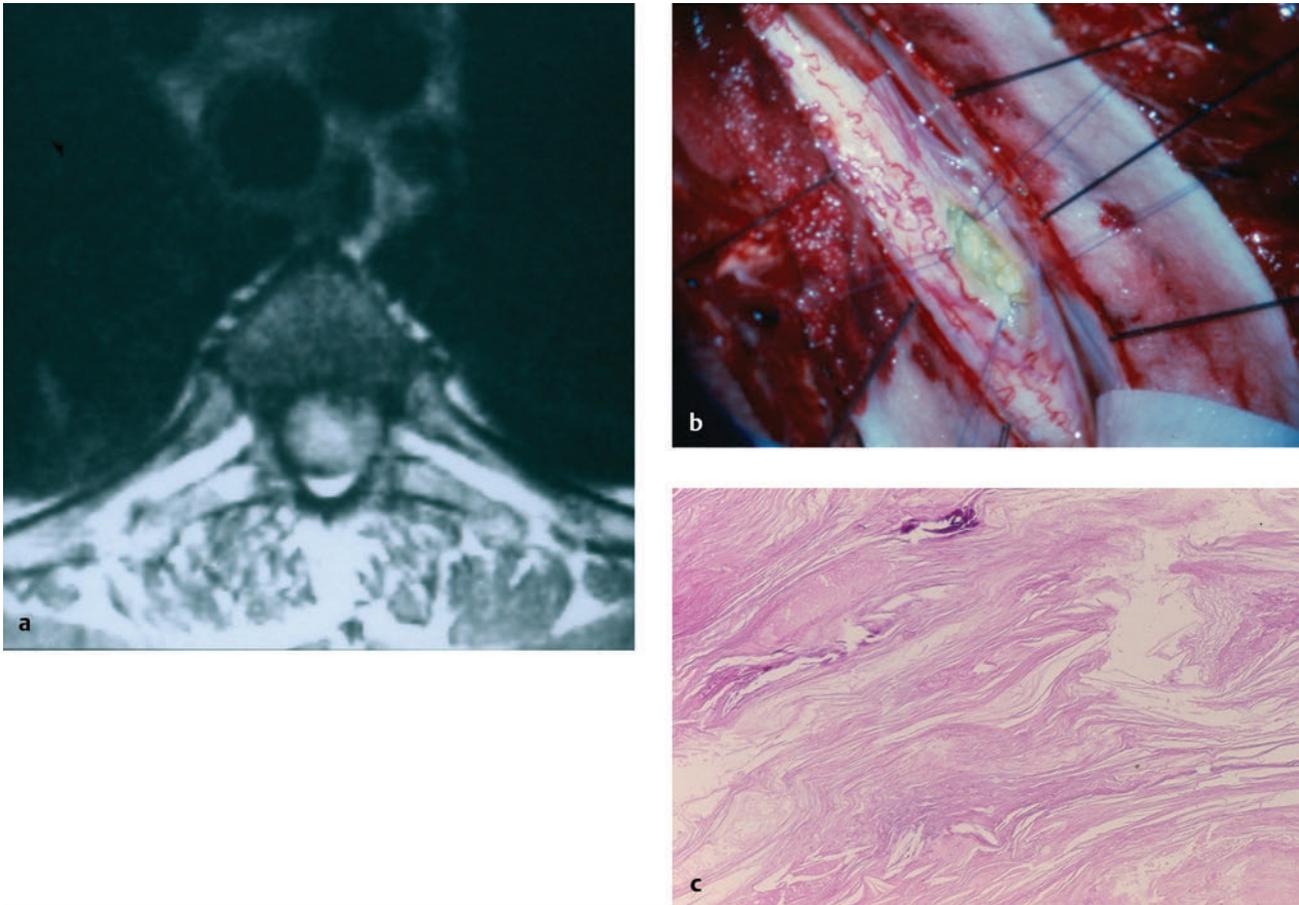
Epidermoid cyst. (a) This epidermoid cyst is hyperintense on axial T2-weighted imaging. (b) Intraoperatively, the lesion was found to be intramedullary, located along the posterior-lateral aspect of the spinal cord (pia retracted with Prolene suture). (c) The membrane showed typical stratified, keratinized squamous epithelium.
